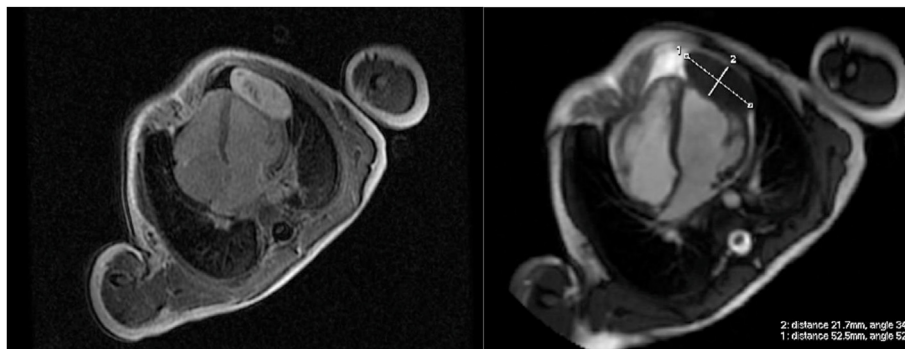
Cardiac magnetic resonance imaging depicting a left ventricular free wall fibroma.
